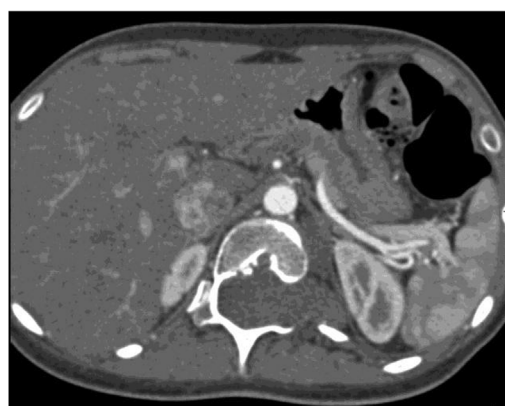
A 19-year-old woman with neurofibromatosis type 1 presenting with left lumbar pain. Contrast-enhanced thoracoabdominal CT images with axial (a) and coronal (b) reconstruction demonstrate an elliptical, hypodense, well-delimited, non-enhancing mass (plexiform neurofibroma) extending through an enlarged thoracic neural foramen to the left paravertebral region of the inferior region of the posterior mediastinum. Note also the presence of scoliosis.
